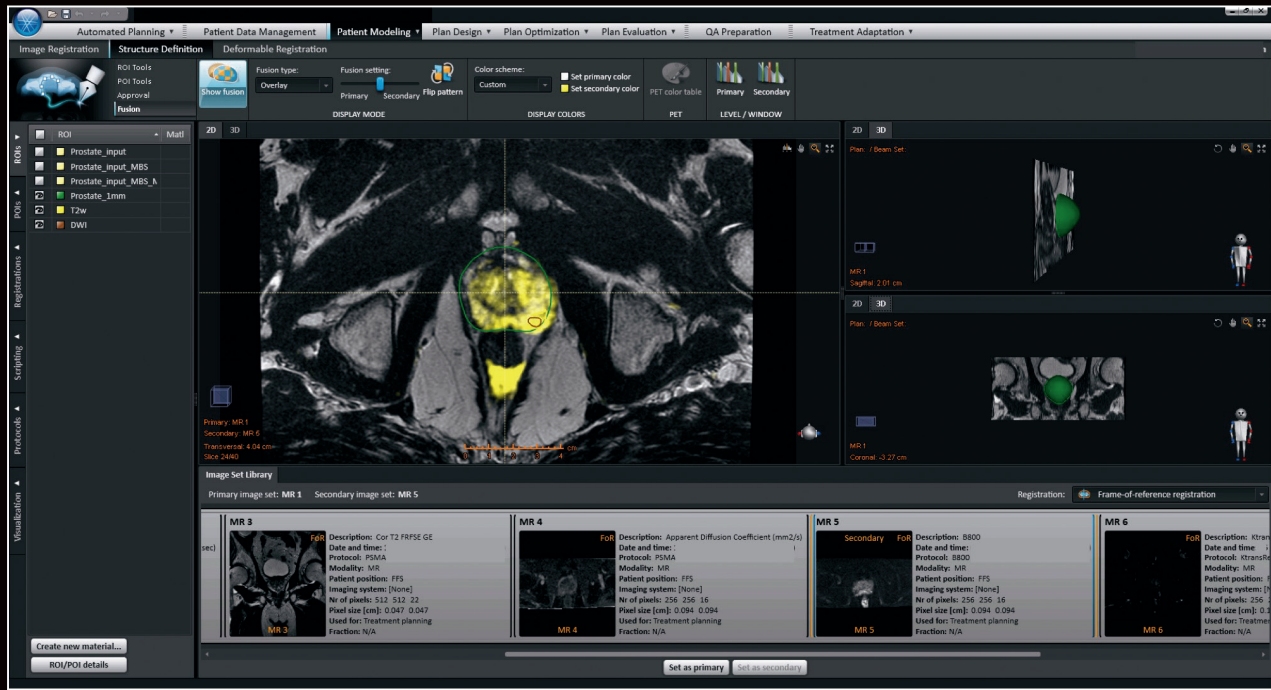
Patient MR images in a treatment planning system, demonstrating an overlay of diffusion b800 on a T2w MR image. The patient was imaged with PET/MR and PSMA-tracer and the delineated subvolume within the prostate represents the PSMA uptake. Umeå is in the validation phase for planning radiotherapy based on PSMA.
